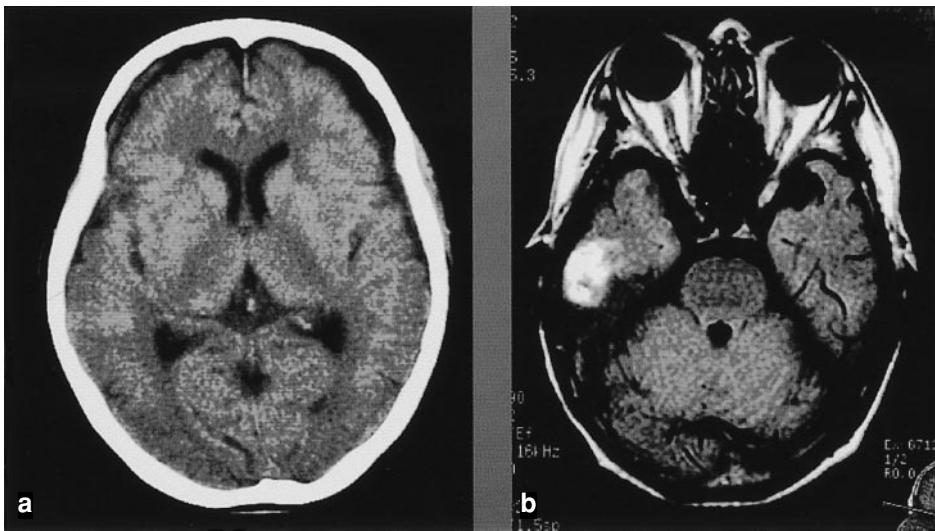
A CT scan demonstrated a thin right subdural hematoma (a). MR imaging on Day 5 showed a right temporal contusion (b)
